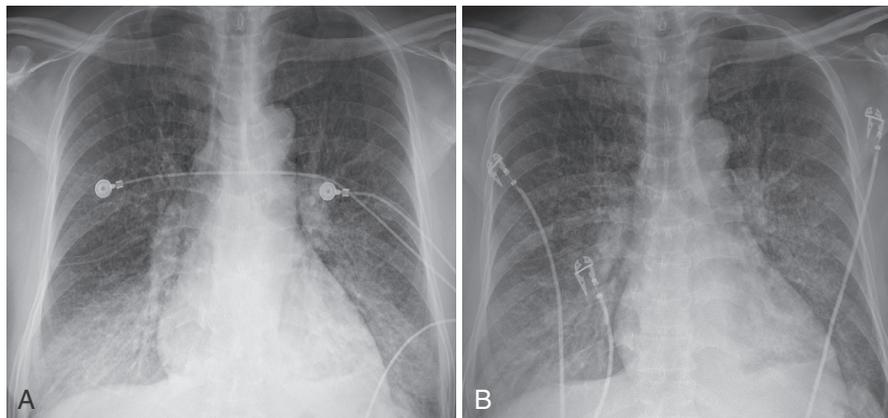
PA chest radiographs in a patient with chronic heart failure after several myocardial infarctions. A, CXR shows chronic interstitial pulmonary edema. B, CXR in the same patient following a new myocardial infarction, showing acute on chronic pulmonary edema.
